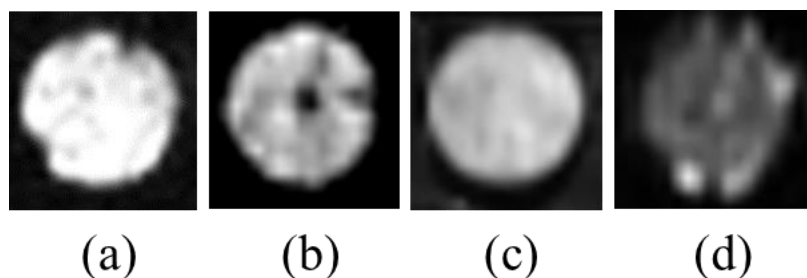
MRI images of $\text{Gd}_2(\text{SO}_4)_3$ /PNIPAM system.
